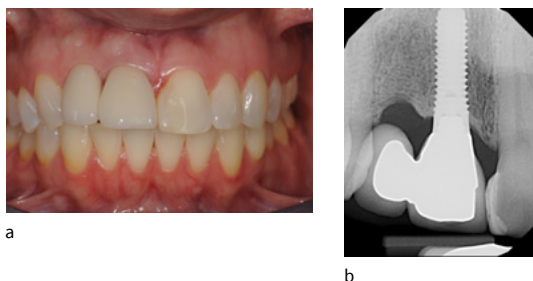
Right-central and lateral incisors replaced with cantilever bridge supported by a tissue level implant 8 years post-op. a: Facial view showing discoloration and graying of the labial gingiva near the margin. b: Radiograph showing excellent crestal bone maintenance
